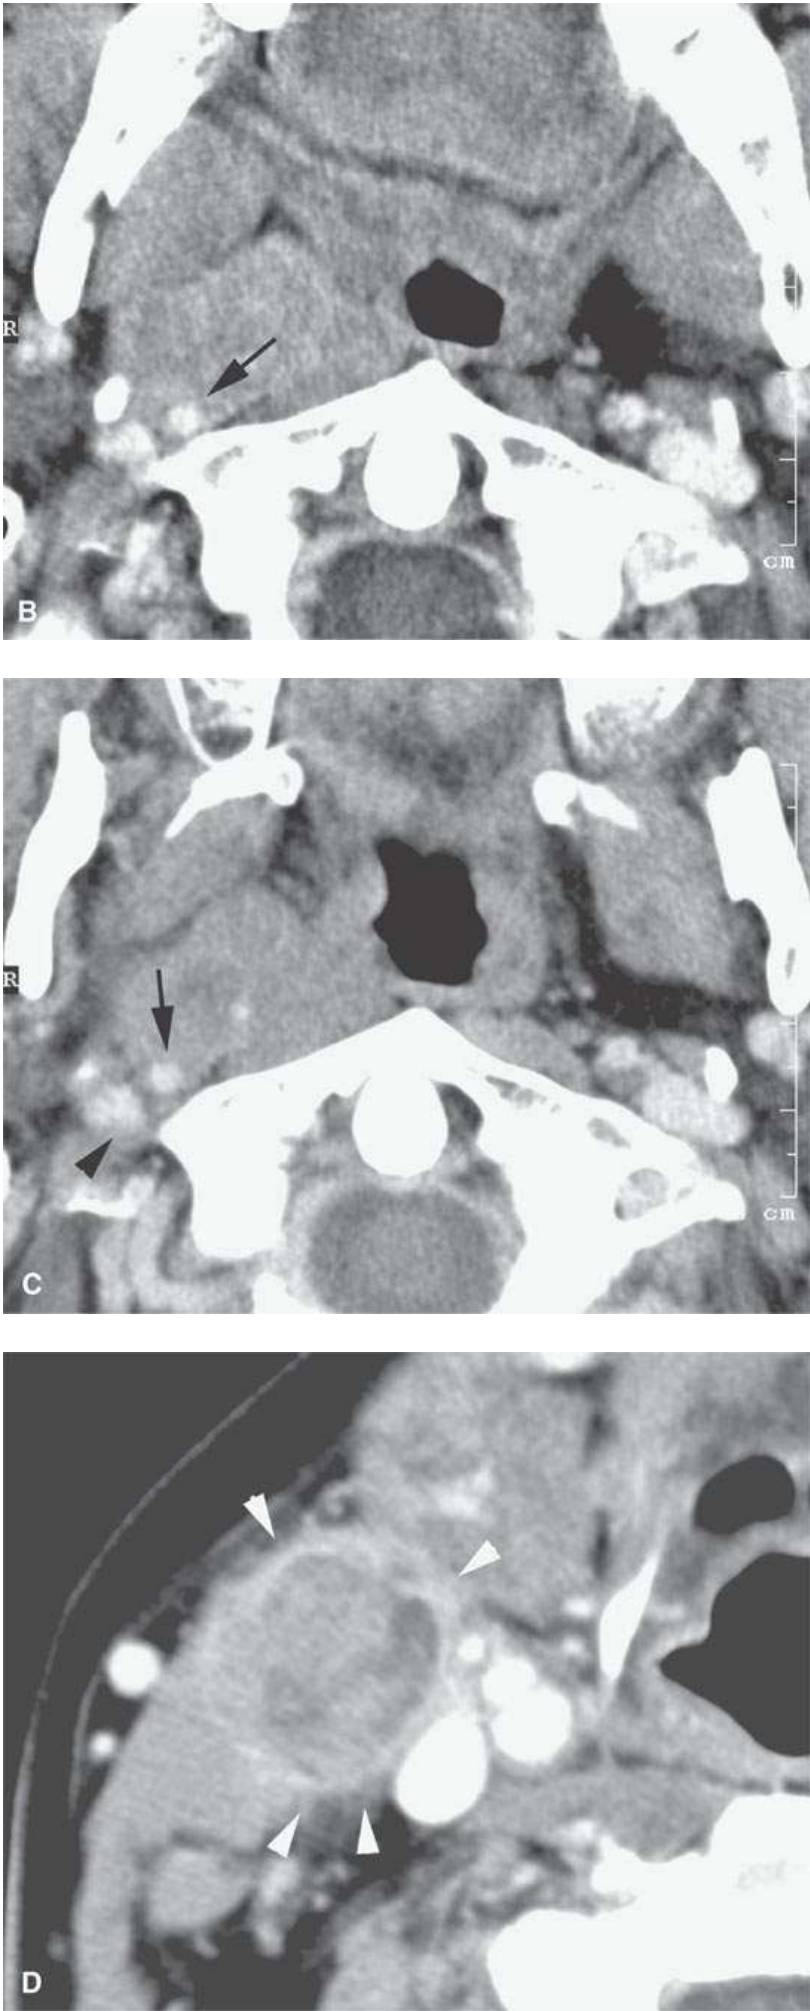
Contrast-enhanced computed tomography in a patient with tonsillar squamous cell carcinoma. A: The indistinct margins are a sign of aggressive behavior. The tumor breaks out of the tonsillar bed to invade along the stylopharyngeus muscle to the carotid sheath (*arrowheads*). B, C: The tumor continues to spread in the parapharyngeal space along the carotid sheath within the retrostyloid parapharyngeal space (*arrows*). D: The metastatic lymph node also reflects the aggressive nature of the cancer showing extranodal spread manifesting as indistinctness in the perinodal soft tissues (*arrowheads*).
